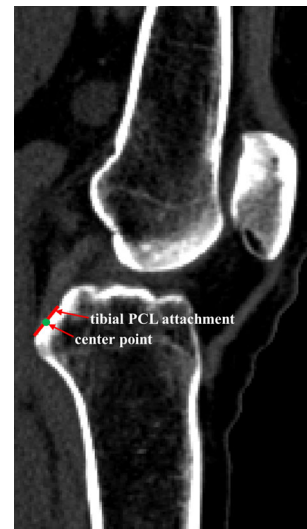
The center point of the PCL attachment was determined on the sagittal-plane of the knee's CT image
